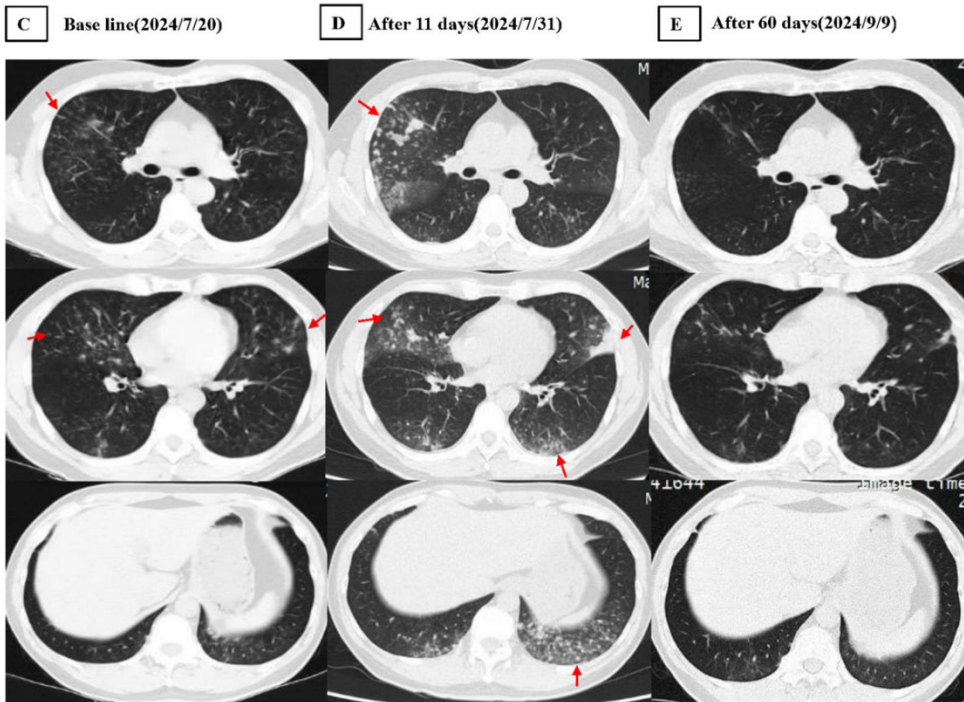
The chest computed tomography CT of case 1.
